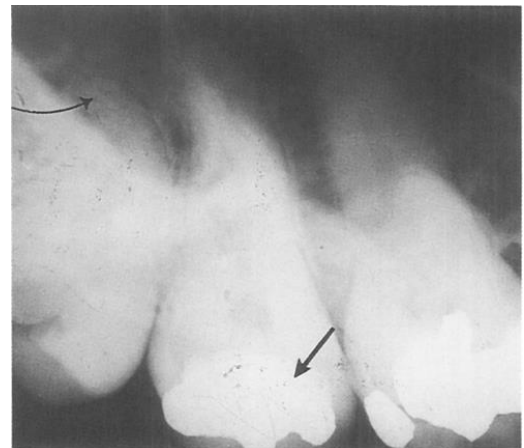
Radiograph of the upper right molar from the patient record. Note similarities relative to Figure 25 (arrows).
